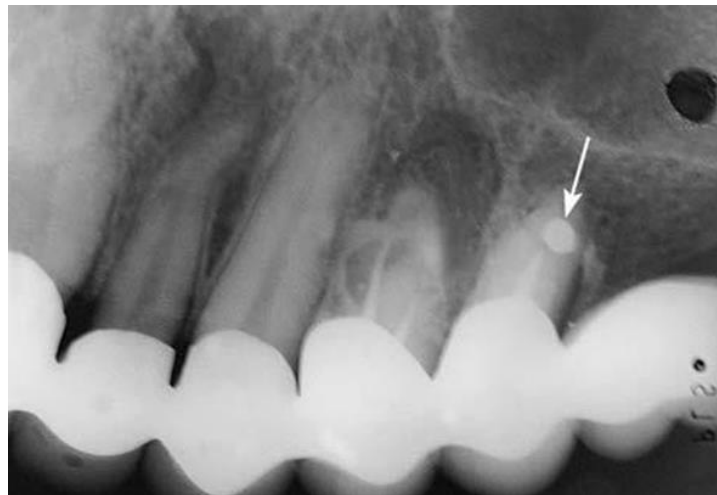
Periapical radiograph showing unsatisfactory apicoectomy at maxillary second premolar, due to failure to define root before resection (Fragiskos, 2007)
